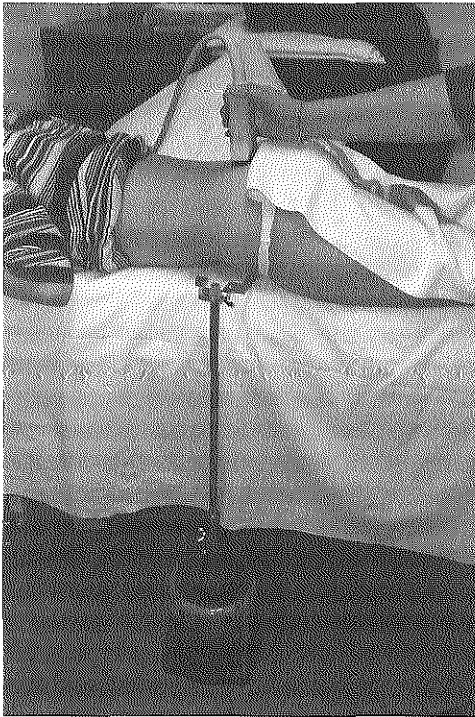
Experimental setup showing the vibrations propagate in the ilium up to the sacroiliac area. At the dorsal side, the vibrations of the ilium and the adjacent sacrum are picked up by a colour Doppler imaging transducer which covers both sides of the sacroiliac joint.
